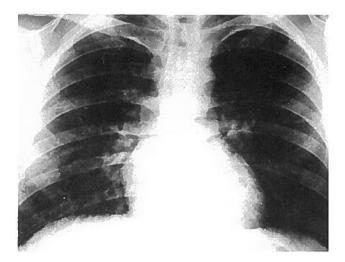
Pulmonary arteriovenous fistula in right lung seen on posteroanterior chest roentgenogram
